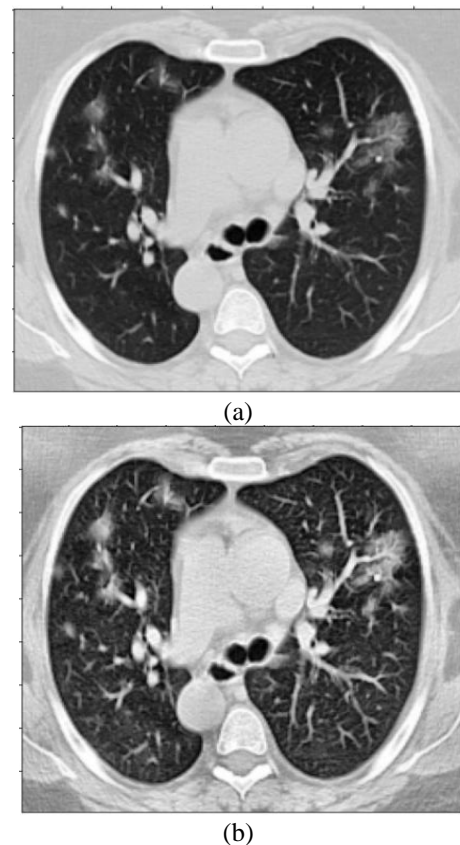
Image CT scan: (a) before preprocessing and (b) after preprocessing
